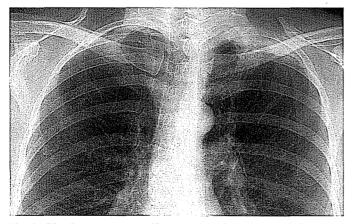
Pancoast tumor. Chest radiograph shows apical pleural thickening associated with destruction of the posterior left second rib.
